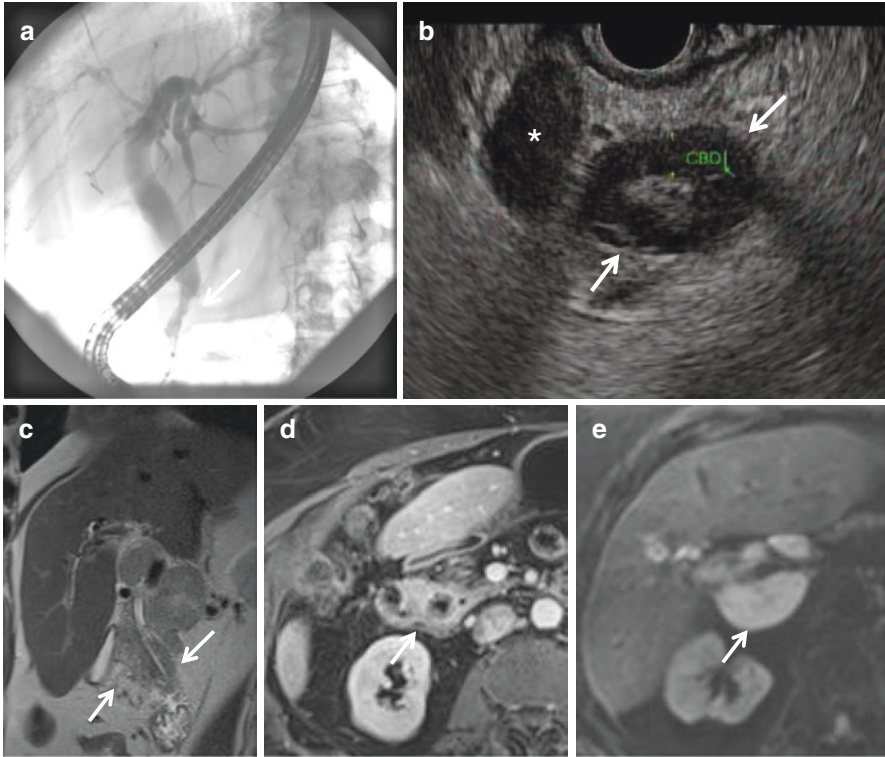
Periductal infiltrating cholangiocarcinoma of the distal common bile duct evaluated with ERC/EUS and MRI. (a) Endoscopic retrograde cholangiography (ERC) shows irregular narrowing of the distal common bile duct (CBD) (white arrow). (b) Endoscopic ultrasound shows marked mural thickening of the distal common bile duct (white arrow) and a large porta hepatis lymph node (white asterisk). (c–e) MRI shows (c) the periductal infiltrating soft tissue with T2-weighted iso- to hypointensity and (d) diffuse enhancement as well as (e) multiple enlarged porta hepatis lymph nodes that demonstrate DWI hyperintensity. MRI magnetic resonance imaging, DWI diffusion-weighted imaging
